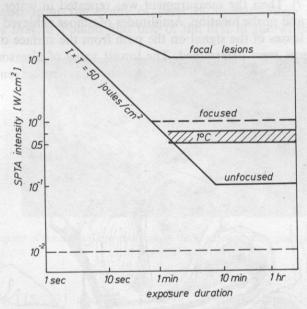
Minimum SPTA (Space Peak Time Averaged) intensities required for ultrasonic bioeffects based on the specified AIUM (American Institute of Ultrasound in Medicine) recommendation. The hatched area corresponds to the lowest intensity levels which may cause a temperature rise of 1 C.
